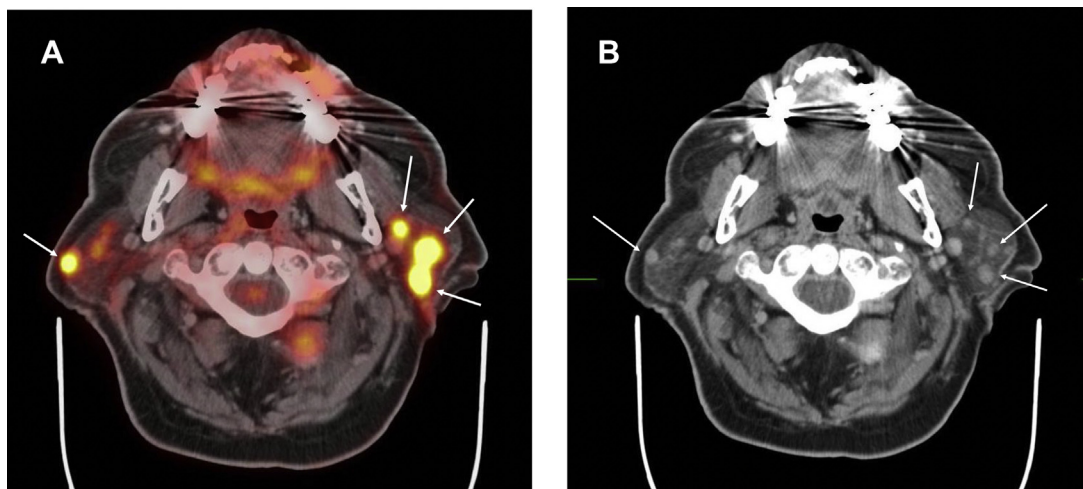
A 77-year-old man with metastatic melanoma and stable hypermetabolic parotid nodules compatible with Warthin tumors. (A) FDG PET/CT fusion imaging showing multiple hypermetabolic parotid nodules (arrows). (B) CT imaging showing multiple parotid soft tissue nodules (arrows).
